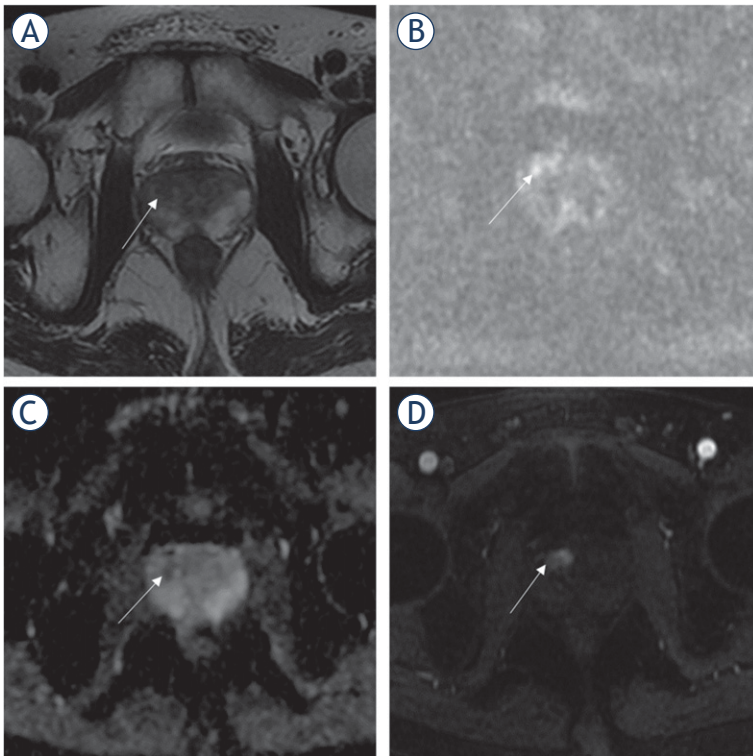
Images from a 62-year-old male patient with a total prostate-specific antigen (PSA) of 7.66 ng/mL. (A) Axial T2-weighted imaging (T2WI) showed focal hypointensity on the right lobe of the prostate in the transitional zone with a blurred margin and a T2WI score of 3. (B) Diffusion-weighted imaging (DWI) showed a slight increase in lesion signal. (C) Reduced corresponding apparent diffusion coefficient (ADC) value with a score of 3. (D) dynamic contrast-enhancement (DCE) showed obvious enhancement in the early stage of the lesion, thus indicating that the DCE score was positive. Scores were 3, 4, and 4 based on T2WI + DWI, T2WI + DCE, and T2WI + DWI + DCE, respectively. The lesion was confirmed to be clinically significant transitional-zone prostate cancer (cs-tzPCa) based on biopsy (Gleason score of 5 + 4).
